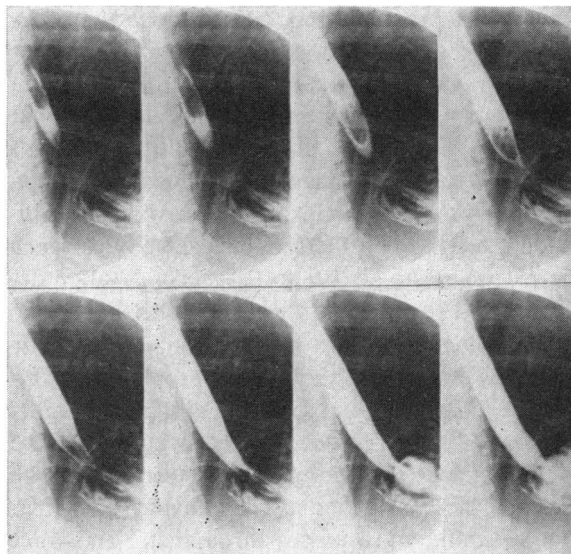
Roentgenographic appearance of vestibular relaxation. With patient supine, serial 70 mm spot films were taken of the lower esophagus during a two-second interval immediately after deglutition of barium. The head of the barium column reaches the vestibule before its relaxation and assumes a V configuration (frames 1 and 2). The empty segment between the V and the stomach represents the vestibule. As the vestibule relaxes, barium flows through its lumen to enter the stomach. (Through the courtesy of W. B. Saunders Company, publishers, Radiologic Clinics of North America 7:147-161, April 1969.)
